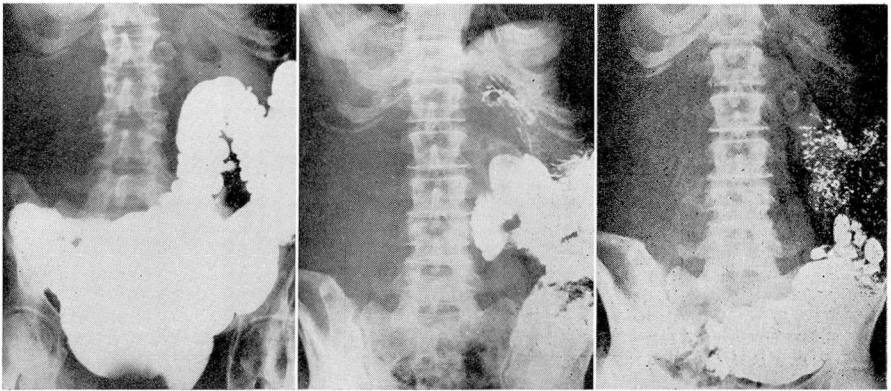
(a)Roentgenogram showing transverse and ascending portions of the colon, displaced downward and toward the midline by the large right abdominal mass, and calculus in gallbladder, also displaced to the left.
